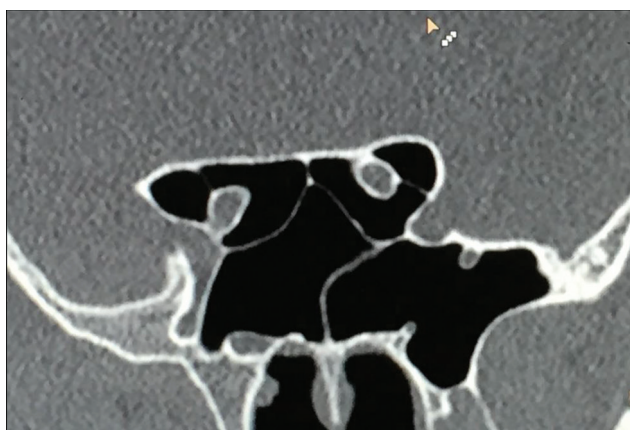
Coronal CT image of a 25-year-old male showing type IV Delano's classification of optic nerve relation to the sphenoid sinus.
